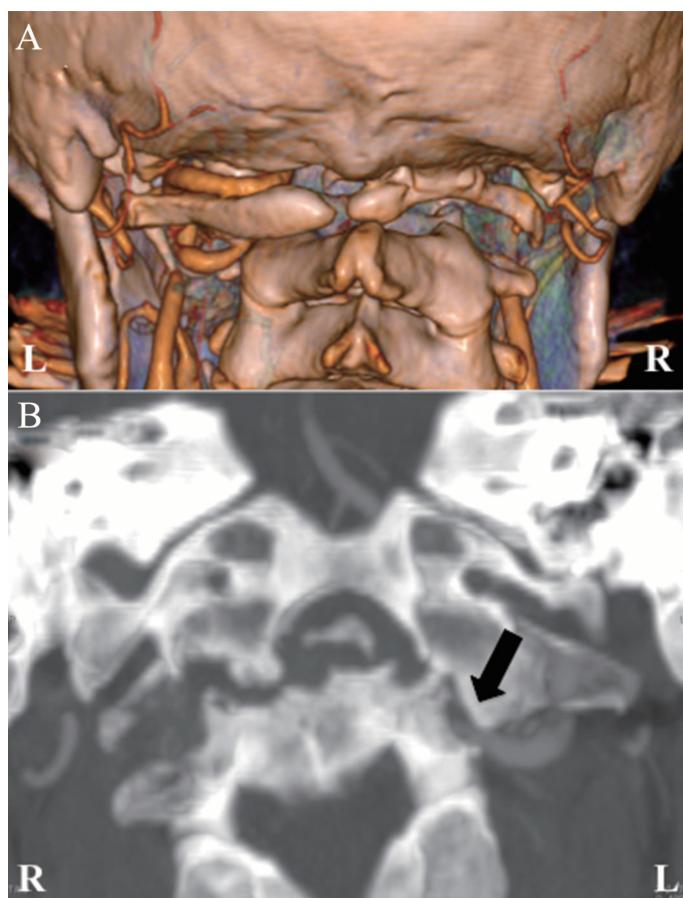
3D-CTA of craniocervical junction. A, Posterior 3D-CTA view reveals lateral subluxation of C1–C2 and dysraphism of the C1 posterior arch. B, Coronal reconstruction image of the craniocervical joint reveals erosive change in the lateral subluxation of C1–C2; the left vertebral artery was osseously wedged at the transverse foramen of the axis (arrow). 3D-CTA indicates 3-dimensional computed tomography angiography.
